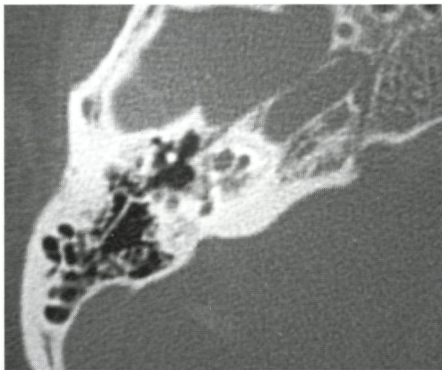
Imaging in Case 2; preoperative CT scan right petrosal bone (transversal view): pericochlear lucency - double ring effect - and narrowed basal turn (Type 2c).
